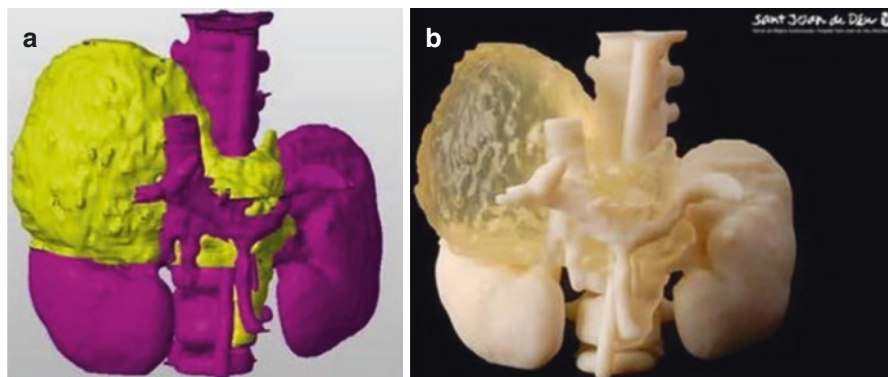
(a) 3D virtual reconstruction of a tumor encasing major vessels from CT and MR fusion images. (b) 3D-printed prototype. Tumor is represented in a semitransparent, “operable” consistency. (With permission from Krauel et al. License Number 4841070538391)
